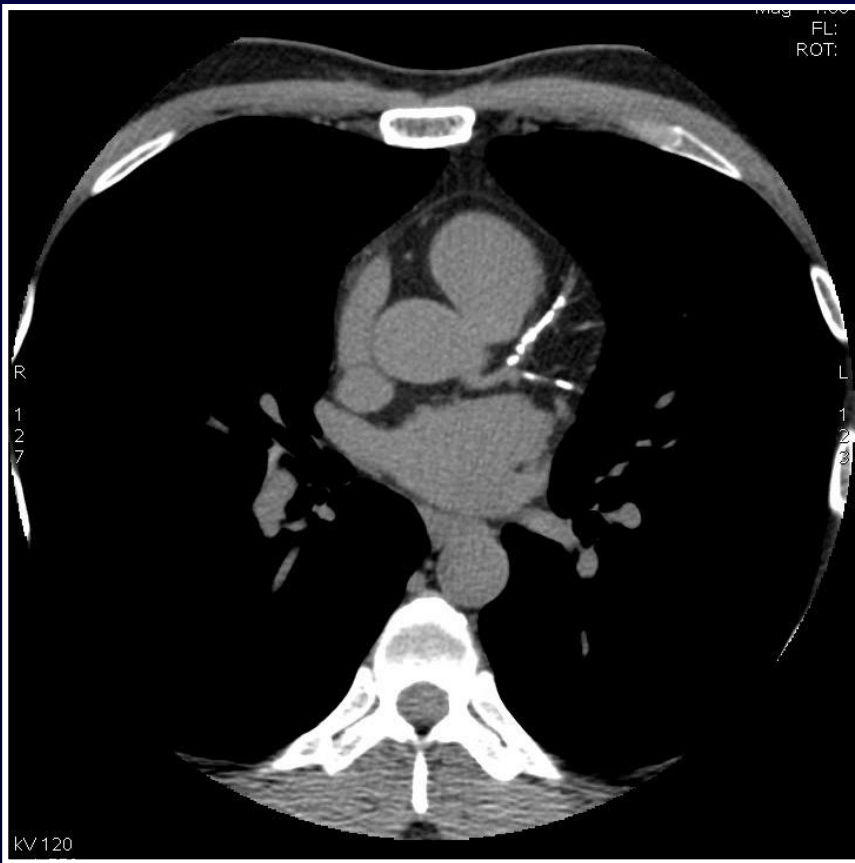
Image-Based Assessment of CVS Risk : CT Calcium Score Test
